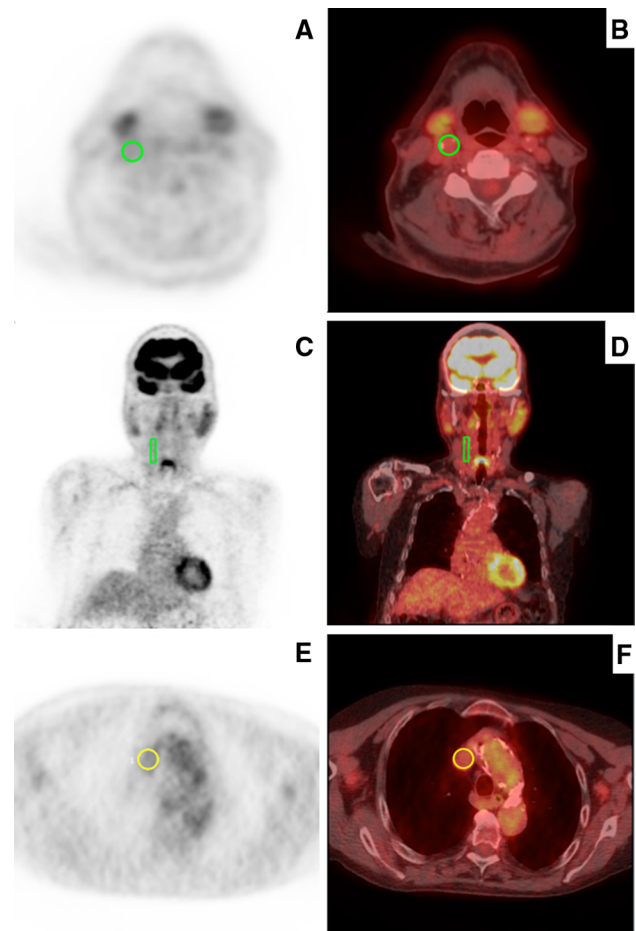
^{18}F -FDG PET/CT images: a Positron emission tomography (PET) image of a transverse section with the region of interest (green) around the carotid plaques to analyse; b fusion CT/PET image of a transverse section with the region of interest (green) around the carotid plaques; c Positron emission tomography (PET) image of a coronal section with the region of interest (green) around the carotid plaques; d fusion CT/PET image of a coronal section with the region of interest (green) around the carotid plaques; e Positron emission tomography (PET) image of a transverse section with the region of interest (yellow) around the superior cava vein; f fusion CT/PET image of a transverse section with the region of interest (yellow) around the superior cava vein
